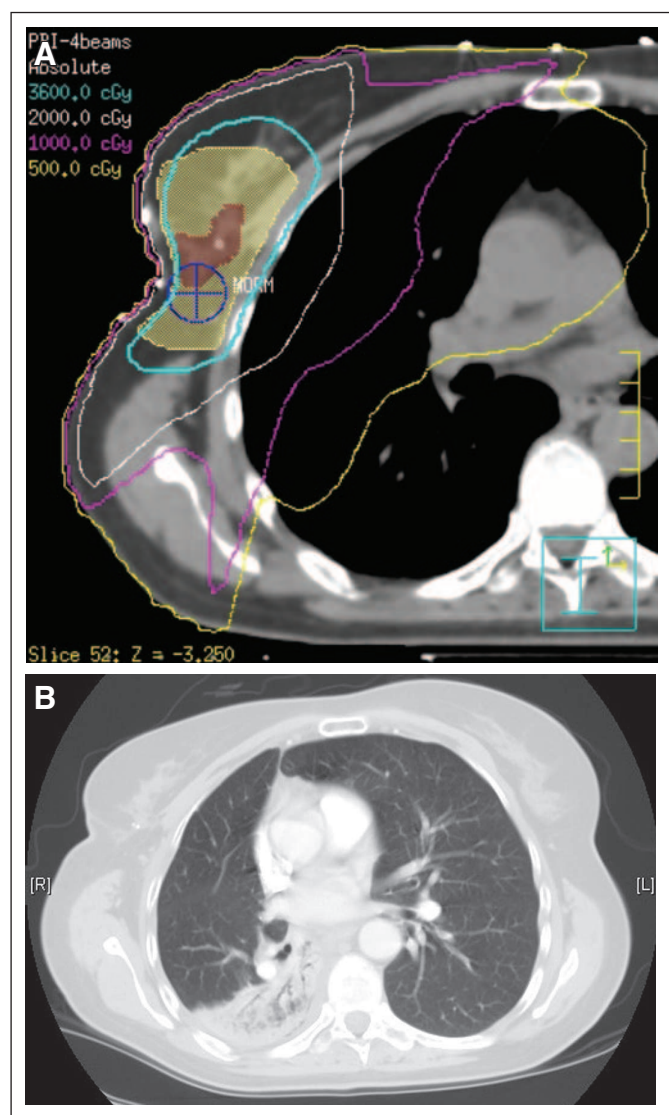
(A) Dose distribution showing 36-Gy (blue), 20-Gy (white), 10-Gy (purple), and 5-Gy (yellow) isodose lines superimposed on planning computed tomography (CT) for patient 1. Brown color-wash, excision cavity; yellow color-wash, planning target volume. (B) Diagnostic chest CT for patient 1 at time of diagnosis of pneumonitis at the same level as Figure 1, showing sparing of the directly irradiated lung. Note the surgical clips marking the excision cavity.
